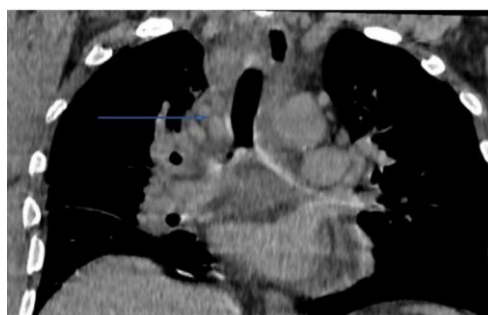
Chest CT in coronal section, mediastinal window, showing multiple hila-mediastinal nodes
